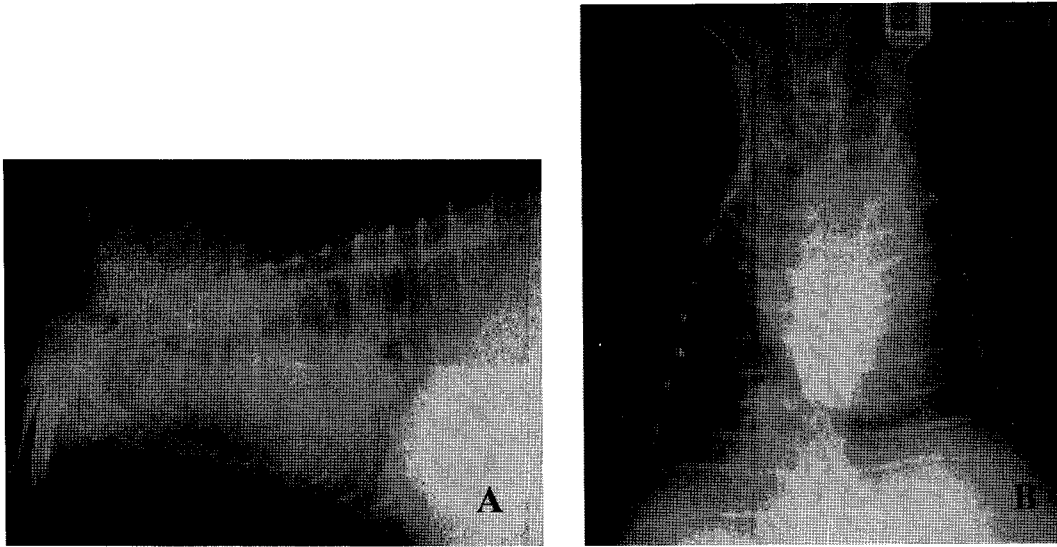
(A) A right lateral radiograph depicting a large and soft tissue opacity mass with unclear boundaries surrounding the aortic region and extending to the cranial mediastinum. (B) A ventrodorsal radiograph showing severe widening of the cranial mediastinum with predominant left bulging and mild tortuosity and dilation of the right caudal pulmonary artery.
